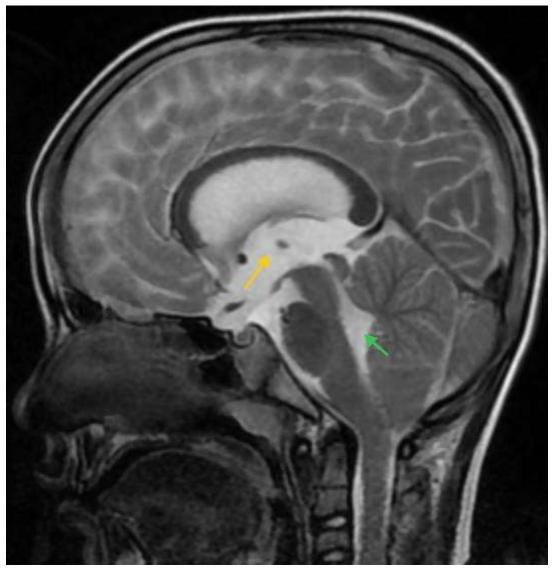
T2 Sagittal MRI showing dilated third (yellow) and fourth (green) ventricles
